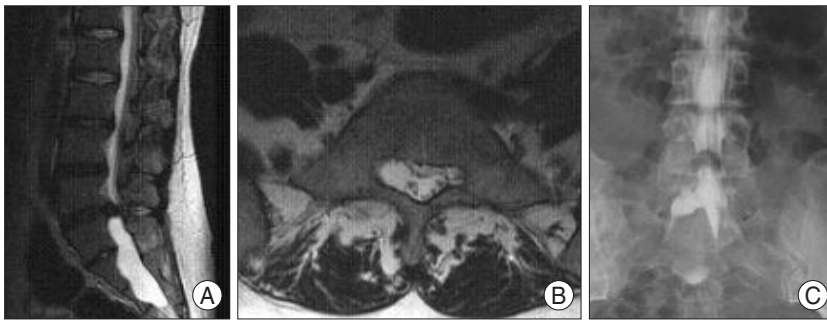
A : Preoperative T2 weighted sagittal magnetic resonance imaging (MRI) indicates the disc herniation at L5-S1 level and space-occupying lesion in the sacrum. B : T2 weighted axial MRI shows cystic lesion compressing the right S1 root. C : Lumbosacral myelogram reveals marked filling defect at L5-S1 level and filling of the cyst with contrast material.
